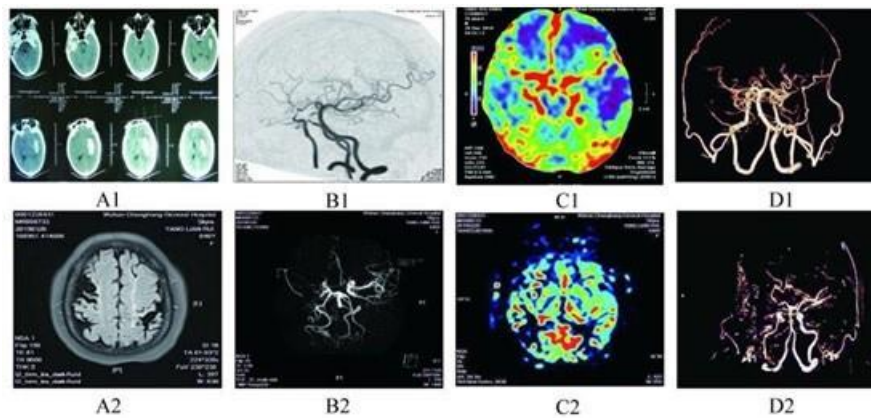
A1-D1 for the brother: (A1) hemorrhage in the left basal ganglia before operation (B1) Computed tomography angiography before operation (C1) the cerebral perfusion imaging before operation (D1) Computed tomography angiography after operation, A2-D2 for the sister: (A2) and (B2) magnetic resonance imaging before operation (C2) perfusion weighted imaging before operation (D2) Computed tomography angiography after operation
